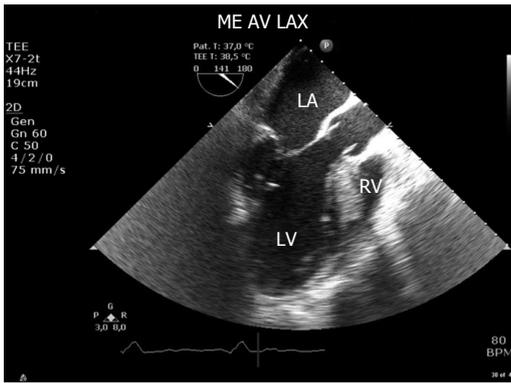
Transoesophageal echocardiography view (mid esophageal long axis view) used to measure left ventricular outflow tract diameter usually best imaged at a multiplane angle of 110°-140°. AV: Aortic valve; LA: Left atrium; LV: Left ventricle; RV: Right ventricle; ME AV LAX: Mid esophageal aortic valve long axis view. Modified by Møller-Sørensen *et al.*^[45].
